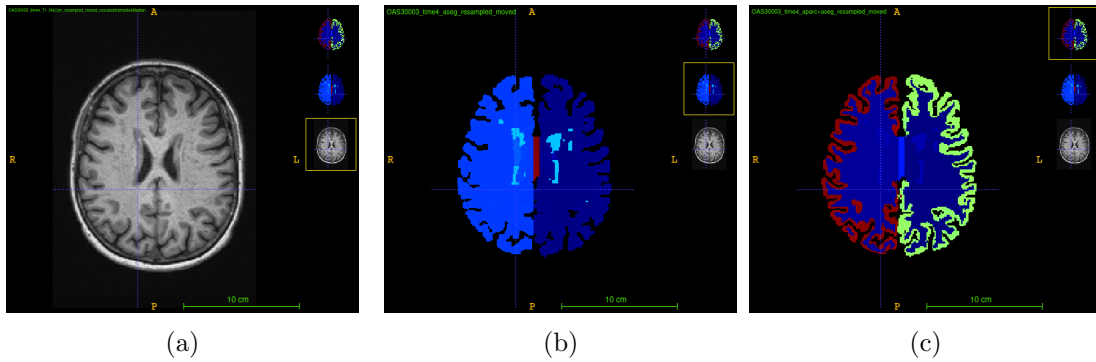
(a) MRI image of OASIS3 patient, (b) Subcortical parcellation segmentation (aseg), (c) Cortical and Subcortical parcellation segmentation (aparc+aseg)
